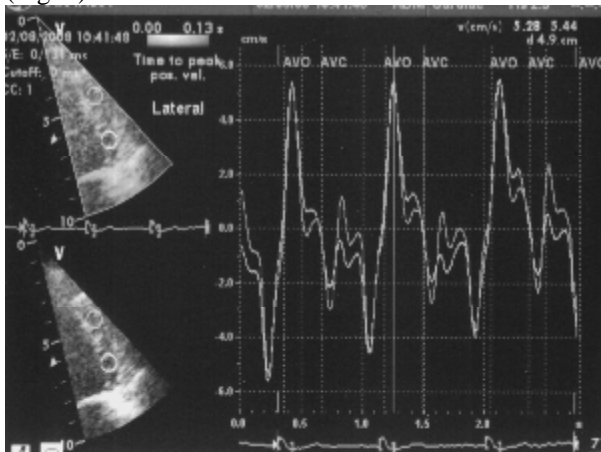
Assessment of left ventricular intraventricular dyssynchrony by Doppler tissue imaging showing no difference in time to peak systolic velocity in base and mid of lateral wall. AVC, aortic valve closure; AVO, aortic valve opening
